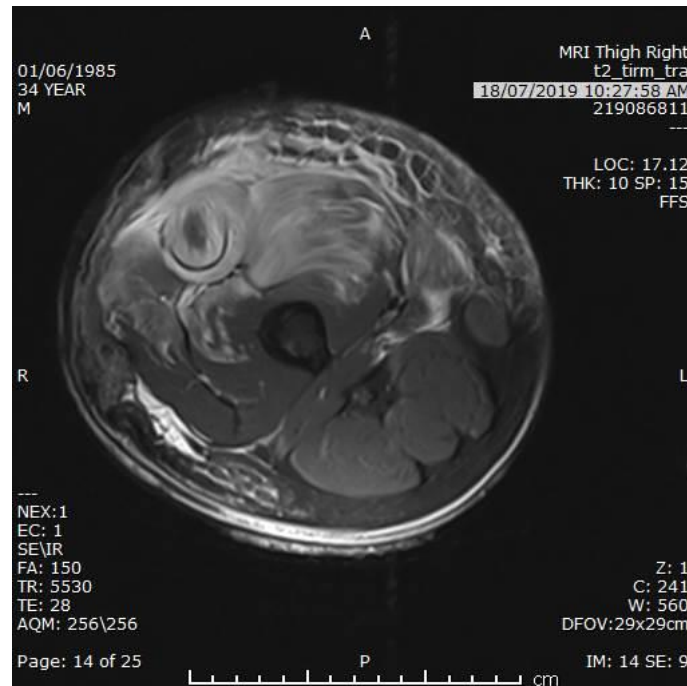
MRI of the right thigh: swelling and hemorrhage of the muscles in the anterior compartment
